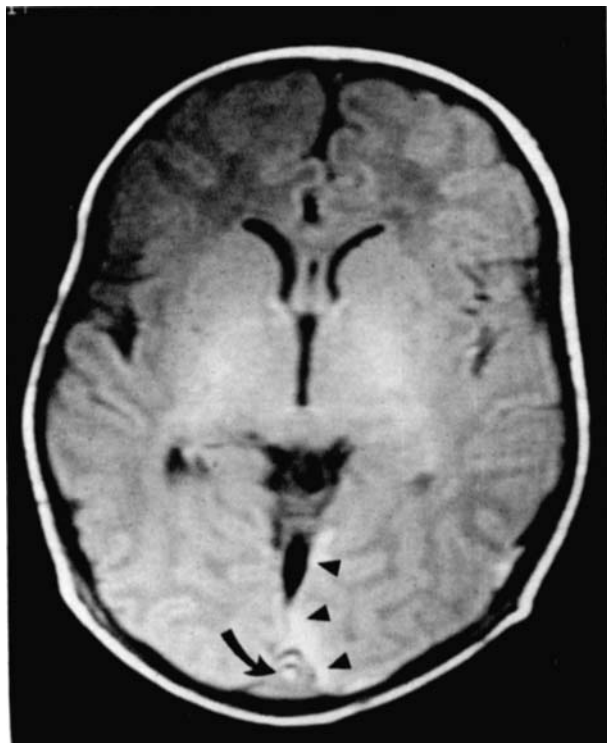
Axial spin echo T1-weighted image of Patient 4, showing the ring appearance of partial thrombosis within the torcular herophili (curved arrow) and subdural hematoma along the medial aspect of the left occipital lobe (arrowheads).
